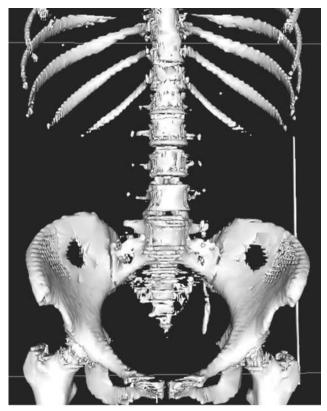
Preoperative CT stonogram 3-D reconstruction showing multiple ureteral stones occupying the left proximal, middle and distal ureteral segments.
